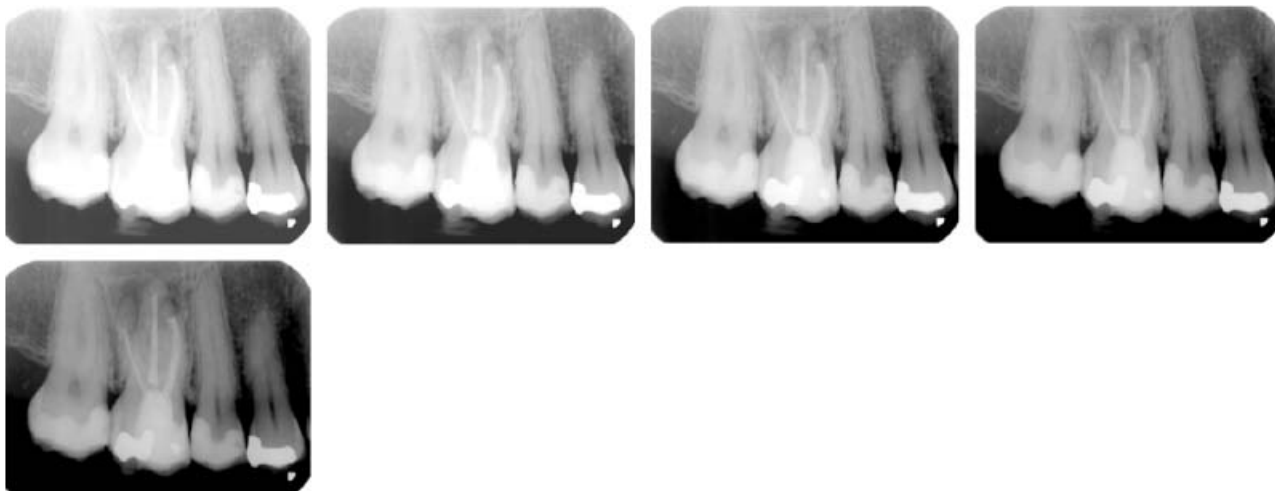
As this radiograph gradually gets darker, the lesions at the apices of the first molar become more visible.
